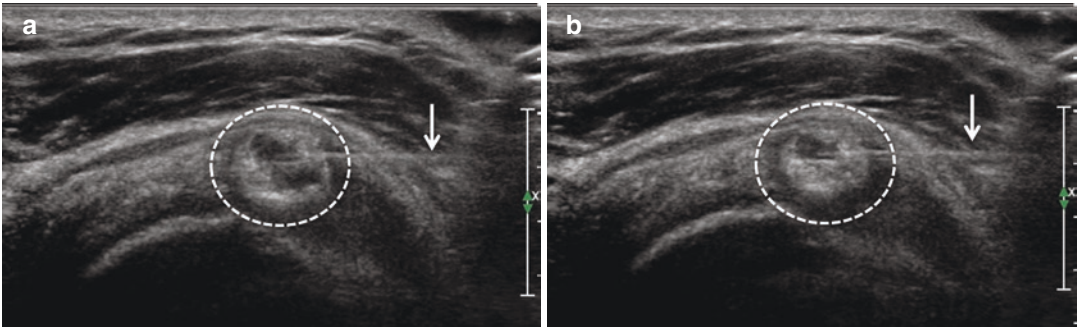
(a and b) Ultrasound images demonstrate distention (a) and decompression (b) of the cavity (circle) within the calcific deposit during lavage and aspiration, producing a “fishmouth” appearance in real time. Arrow—needle
